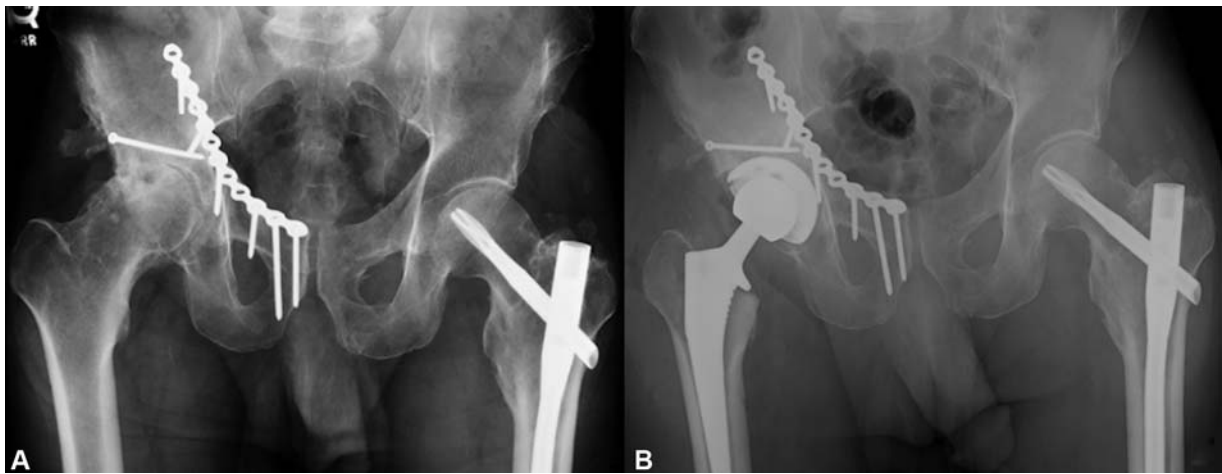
Radiographs of an anterior column fracture treated through an ilioinguinal approach. (A) Preoperative radiograph of the right hip shows anterior plating with post-traumatic arthritis. (B) Postoperative radiograph showing THA in place with retention of all prior hardware. THA, total hip arthroplasty.
